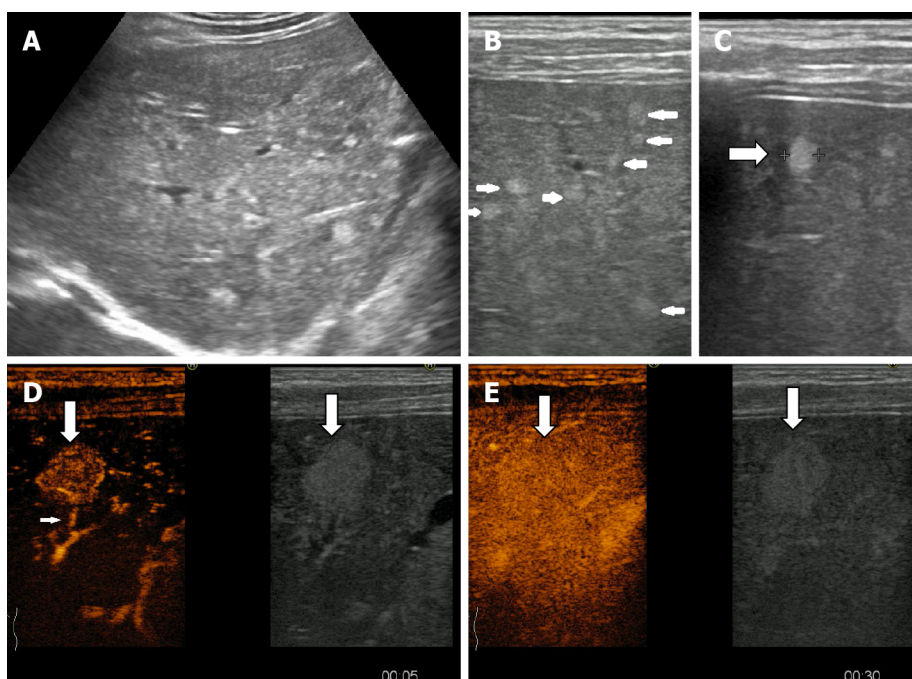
A multinodular pattern of hepatic hemangiomatosis on ultrasound. A: Small hyperechoic lesions are scattered throughout the right liver lobe; B and C: Multiple subcapsular infracentimetric hemangiomas on ultrasound exam using linear probe; D and E: On contrast enhanced ultrasound examination fast-filling hemangioma displaying early homogenous enhancement and visible afferent artery in the arterial phase (D), homogenous enhancement with surrounding parenchyma on early portal phase (E).
